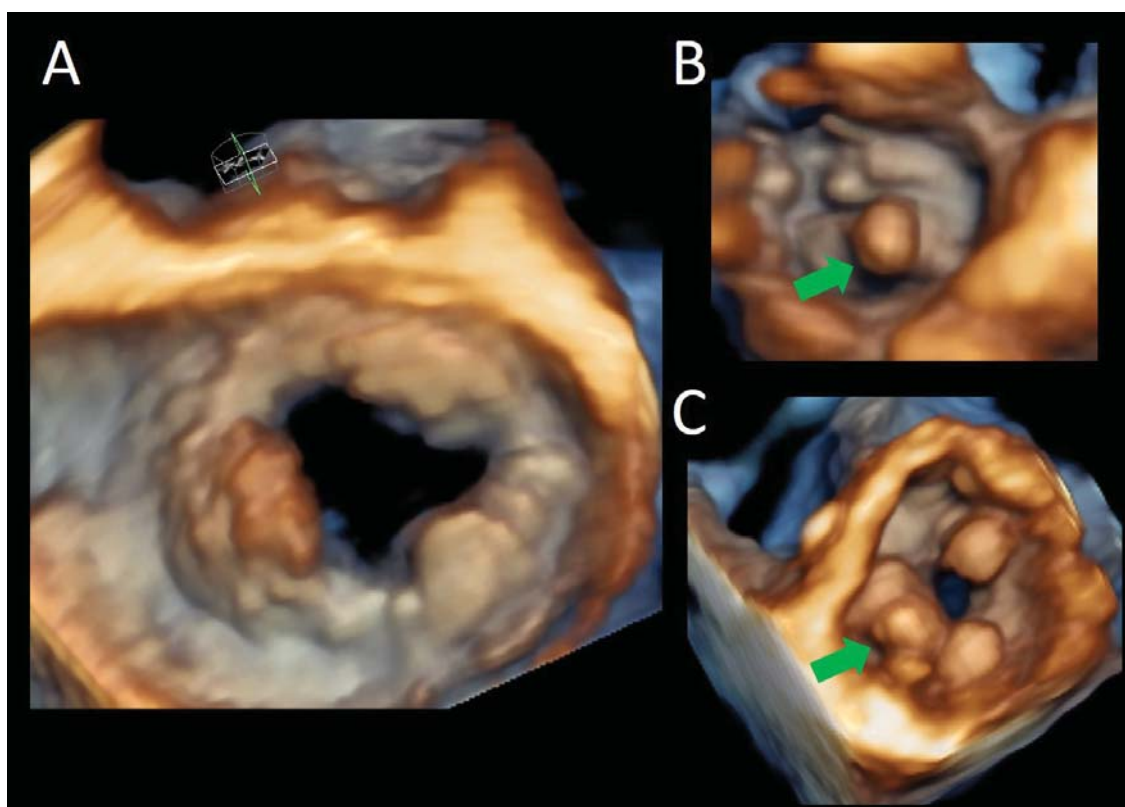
Mitral prosthesis masses. Three-dimensional volume transesophageal volume rendering from the surgical (panel A) and ventricular (Panels B and C) views of a mitral bioprosthesis with signs of degeneration (calcifications, green arrows) and a thrombotic mass (red arrow, between 7 and 10 o'clock).
